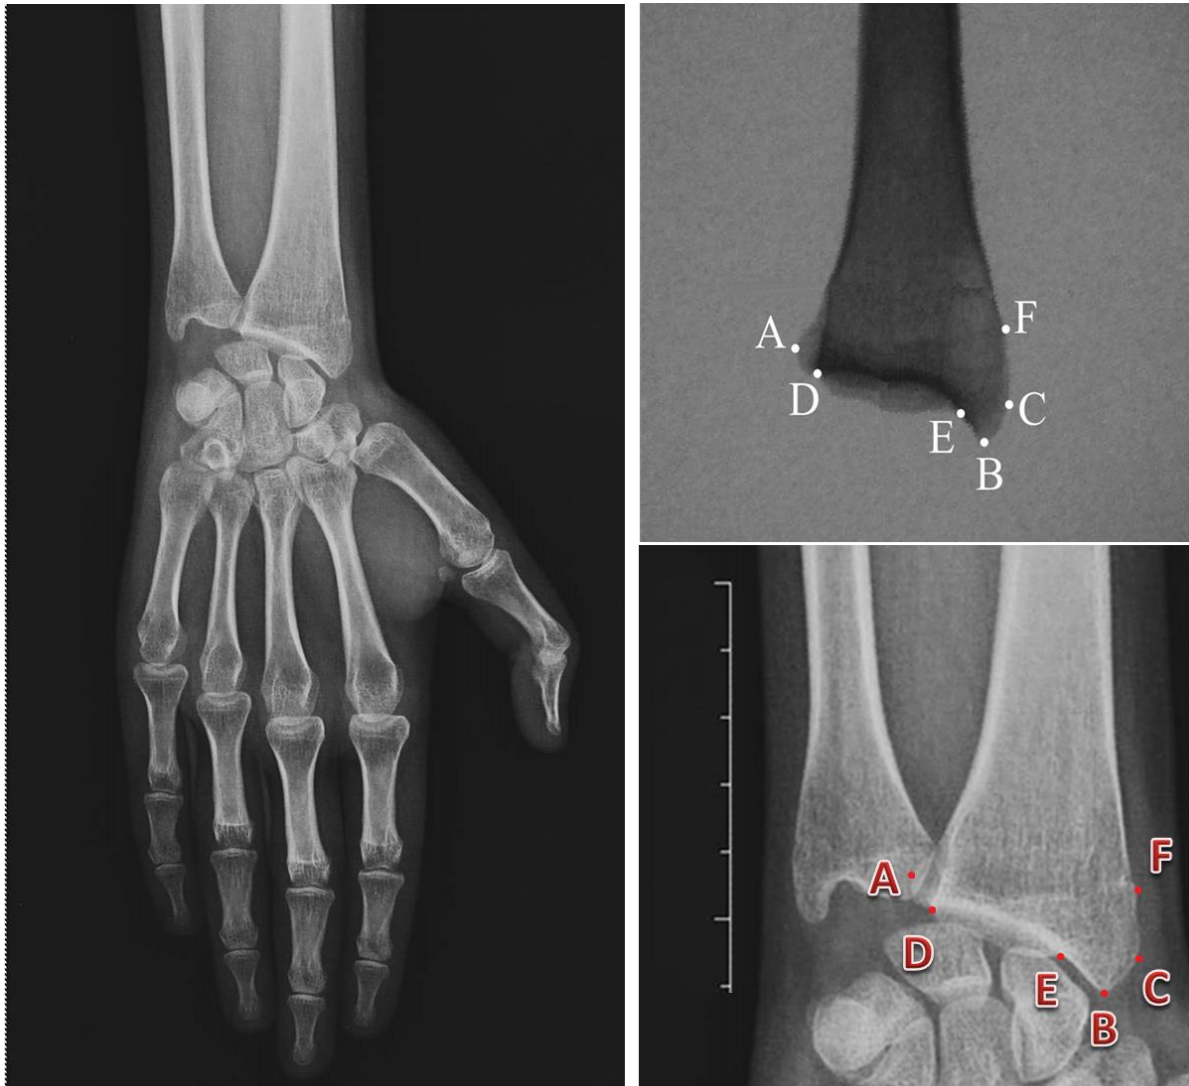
Example of application of the method in a randomly selected radiograph from the hospital's archive.
